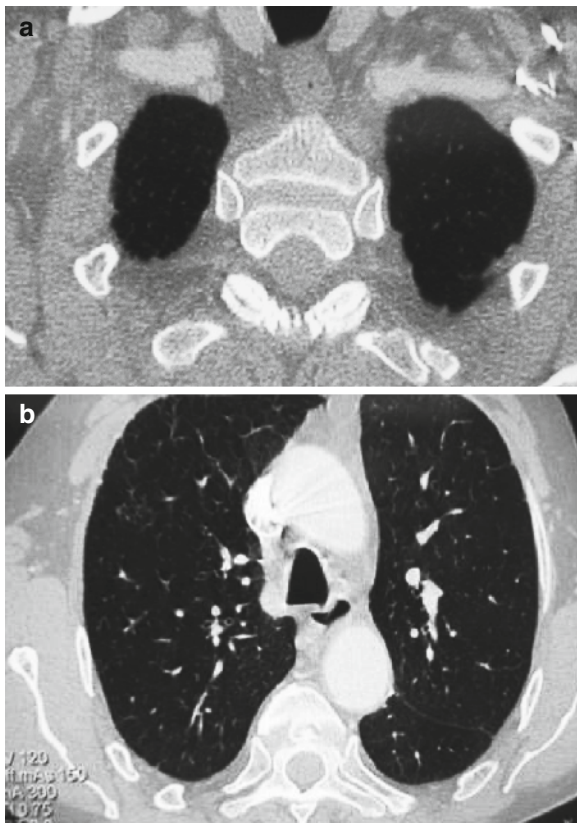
Computed tomography of the chest 60 days before ICU admission. The patient had emphysema, but no other parenchymal lesions. (a) Upper lobes; (b) lower lobes
